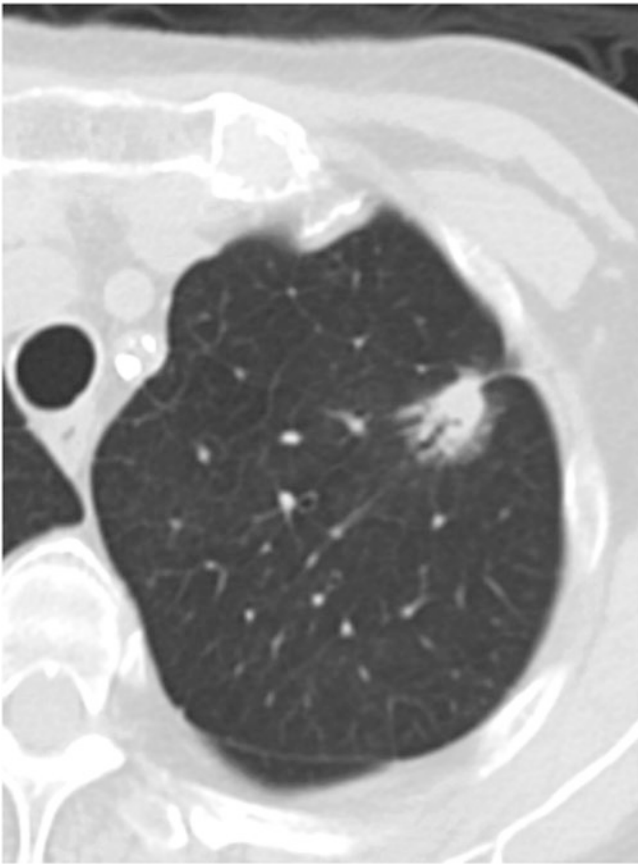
CT imaging shows a mixed solid and ground-glass nodule in the left upper lobe measuring $27 \times 12 \times 31$ mm
